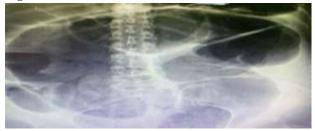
Abdominal X-ray in supine position: A central dilated loop (coffee bean sign) and convergence of radiopaque lines toward the site of obstruction (Frimann-Dahl's sign) are observed.
